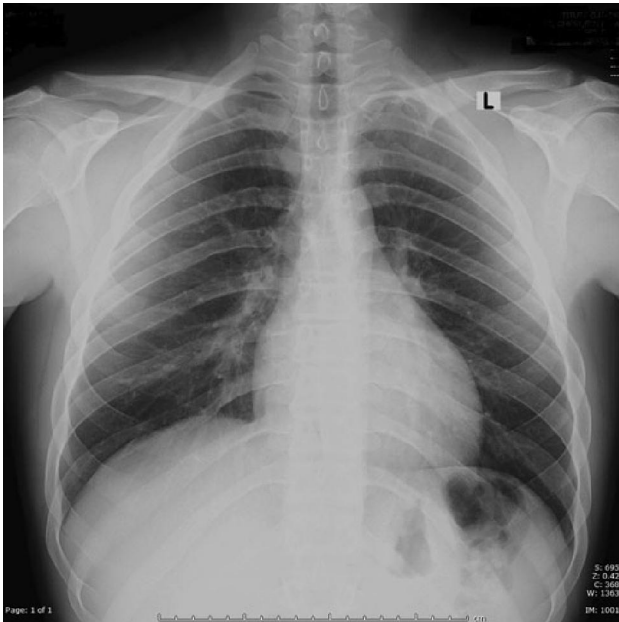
Plain radiograph chest showing lytic lesions in the medial ends of clavicle, more pronounced on the left side.
